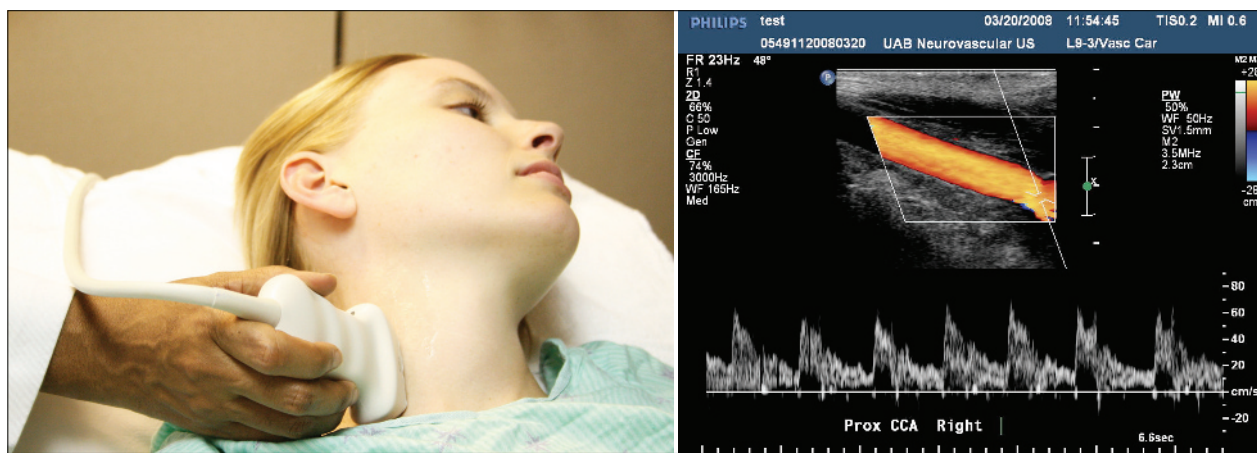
After transverse sweeps, a longitudinal position of the probe yields depiction of the proximal common carotid artery close to its origin from the brachio-cephalic trunk on the right side of the neck. Note that ultrasound image is aligned with the middle of the vessel by keeping "the ends of pipe open." The left side of the ultrasound image is oriented cephalad. Doppler sampling shows the velocity spectra at a 60° angle of insonation.
